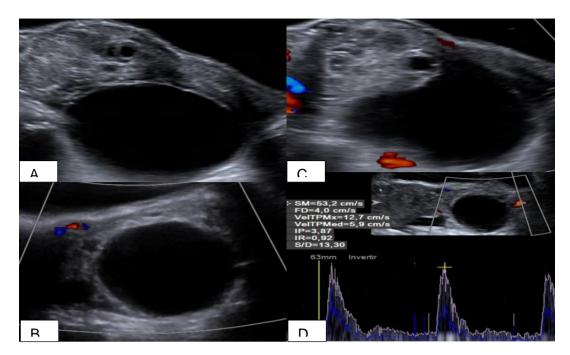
22-year-old patient presenting to the emergency department complaining of sudden, disabling pelvic pain. Images A and B show B-mode ultrasound examination, where a hyperechoic ovary is observed, with a peripheral displacement of the follicles and an image of round morphology, with a thin wall and liquid content compatible with a cyst. After the application of color Doppler (image C), an absence of venous flow is observed, only showing little arterial flow demonstrated by spectral Doppler mode (image D), findings compatible with ovarian torsion and confirmed after performing an exploratory laparotomy in the operating room.
